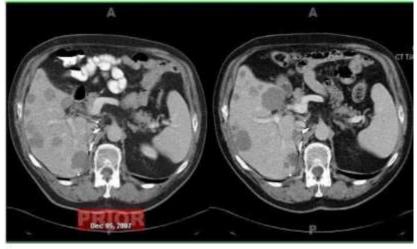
CT scans of the liver from patient with metastatic renal cancer self-administering 40grams of NaHCO3 daily and receiving no conventional therapy since September 1, 2007. Scans from Dec 5, 2007 (left) and April 18, 2008 (right) are shown. These images are representative in that some of the liver lesions have increased in size, some have decreased, and some have remained stable. Interestingly, the central necrosis seen in several of the tumors on the initial scan was no longer present on the follow-up study.
